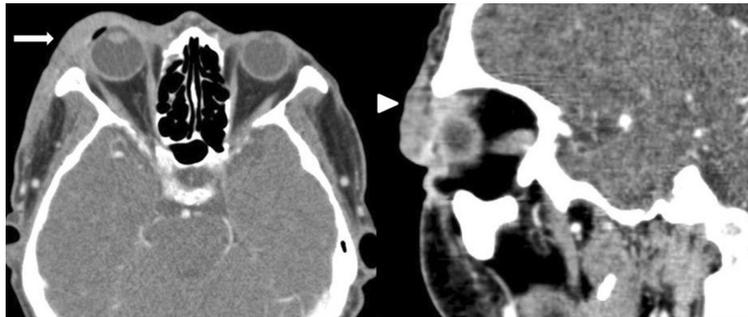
Orbital computed tomography (non-enhanced) demonstrate diffuse skin thickening (white arrow) and subcutaneous layer enhancement (white arrow head) of right periorbital, right zygomatic and right preseptal space.
